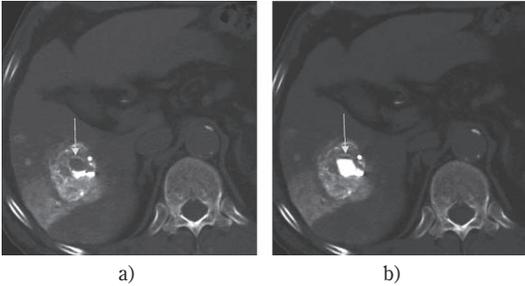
CT arteriography via the feeding artery. On precontrast CT, the cavity in the tumor contains iodized oil in the dorsal region, and the unembolized ventral portion (a, arrow) can be seen. This portion shows overt contrast enhancement after injection of contrast solution via the feeding artery (b, arrow).
